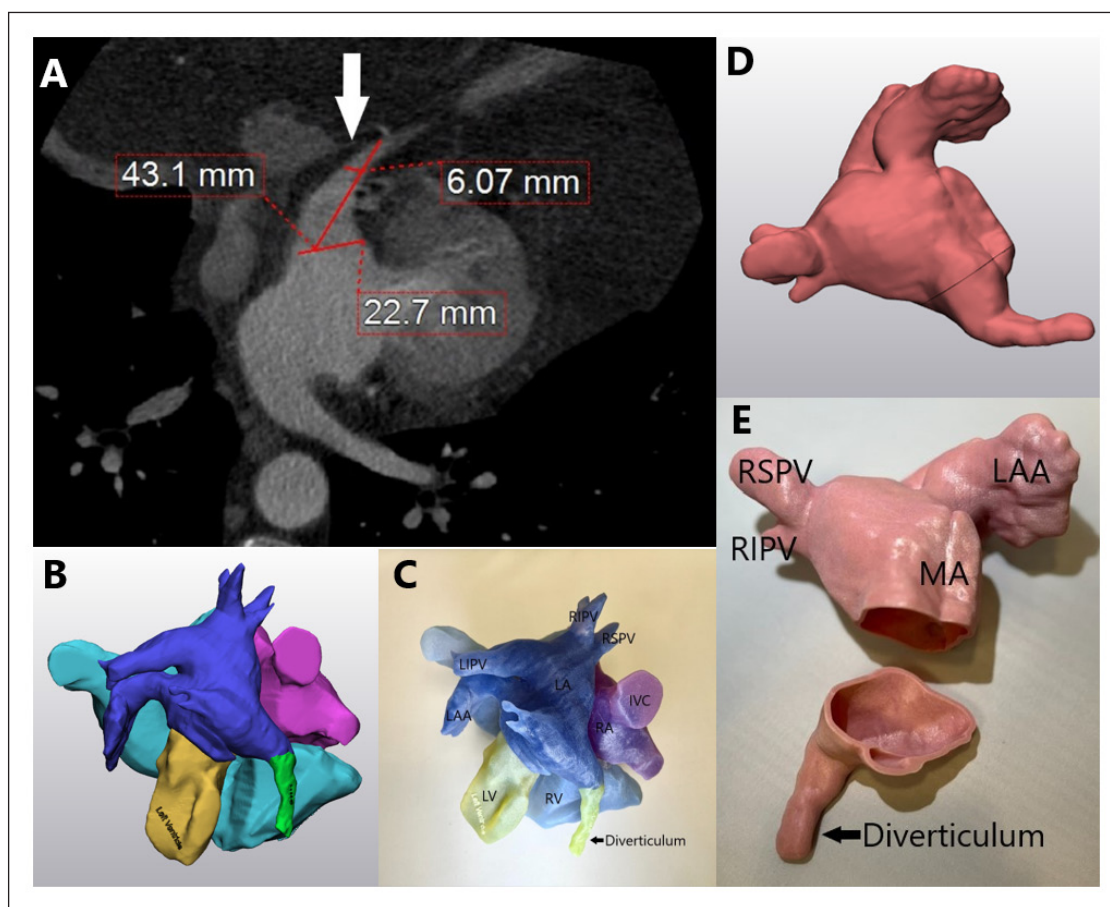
(A) Cardiac computed tomography showed a large left atrial diverticulum (4 cm by 2 cm at the ostium) located on the anterior-inferior aspect of the left atrium that tapered and terminated into the perihepatic fat tissue (white arrow). (B, C) Digital and 3-dimensional (3D) printed models show the left atrium diverticulum in relationship with other cardiac structures. (D, E) Digital and 3D printed models of the left atrium with the inferior portion transected to show left atrium diverticulum in relationship with other left atrial structures. IVC: inferior vena cava; LA: left atrium; LAA: left atrial appendage; LIPV: left inferior pulmonary vein; LV: left ventricle; MA: mitral annulus; RA: right atrium; RIPV: right inferior pulmonary vein; RSPV: right superior pulmonary vein; RV: right ventricle
